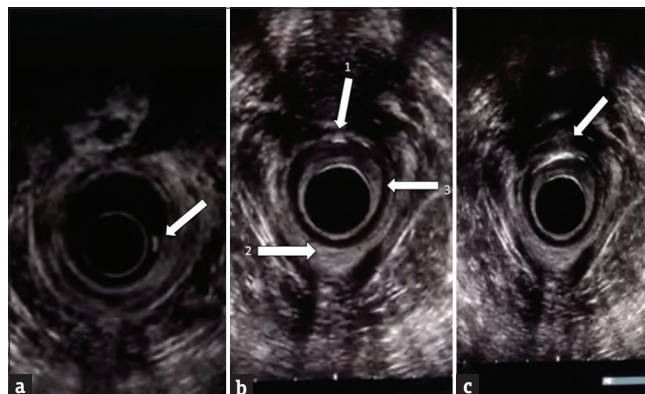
Ultrasonic view during botulinum injection. (a) Arrow shows the tip of the needle at 3 o'clock alignment, (b) Arrow 1 shows the tip of the needle at 12 o'clock alignment, Arrow 2 shows external sphincter and Arrow 3 shows internal sphincter muscle, (c) Hyperechogenic appearance of internal sphincter muscle during the injection
